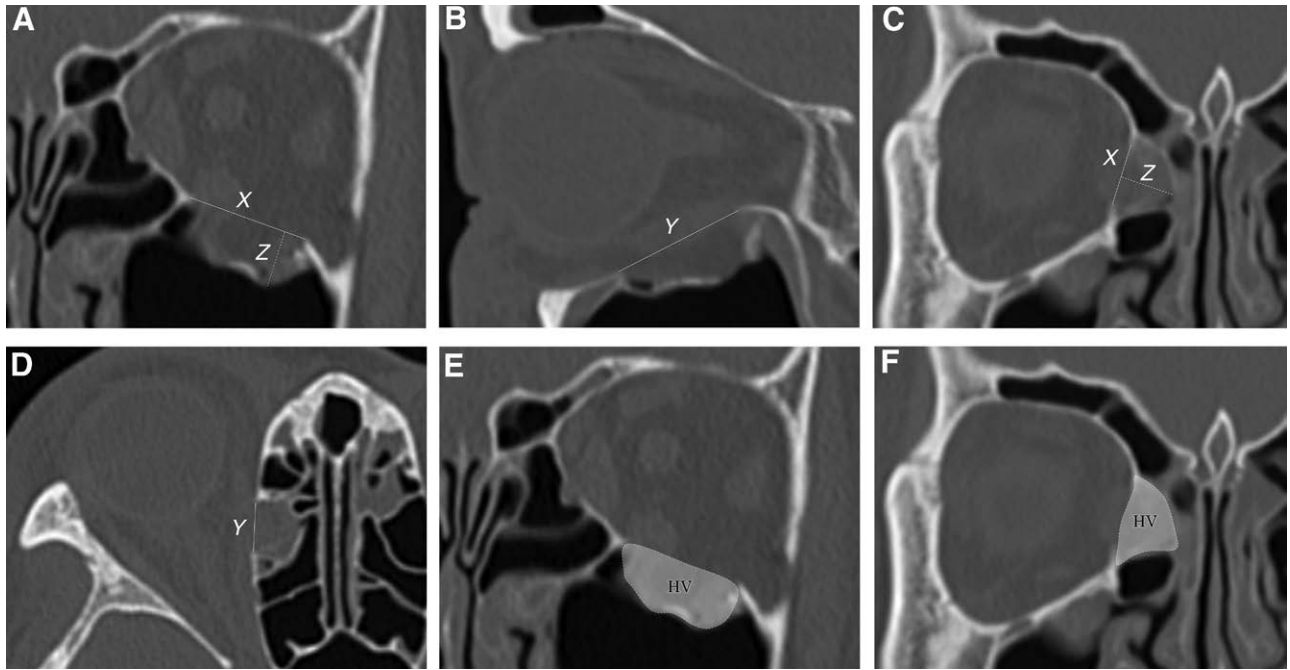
Measurement of CT parameters and HV. A and B, OF fracture. Coronal and sagittal sections were used to define X and Y as the maximum length of the bone defect. On the coronal section, Z was established as the maximum distance the fractured portion moved. C and D, MW orbital fracture. Coronal and axial sections were used to determine X and Y, and Z was determined on the coronal section. E and F, The herniated volume was traced on each coronal slice (dashed line and labeled “HV”).
